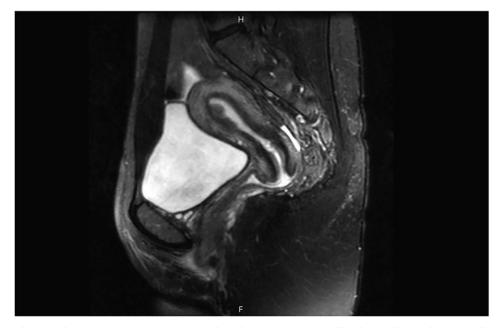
Pelvic MRI demonstrating 1.1 imes 1.3 cm mass along the anterior uterine wall without evidence of myometrial invasion.
